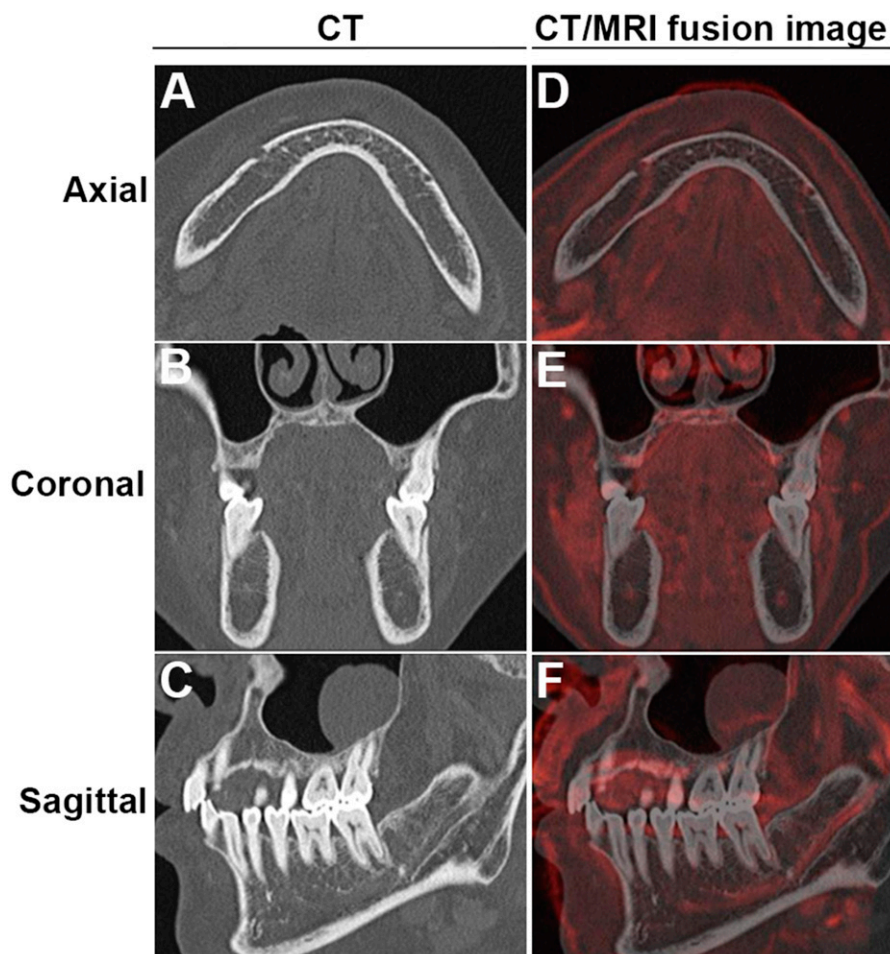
Representative images where neurovascular bundle (NVB) signals could help us identify the course of a mandibular canal (MC) that is not visible on CT. (a–c) are corresponding CT axial, coronal and sagittal (right side) images, respectively, where the MC could not be identified in the premolar (PM) and molar (M) areas. (d–f) are corresponding axial, coronal and sagittal CT/MR fusion images, respectively, that could assist in MC detection. The NVB is depicted as a red structure.
